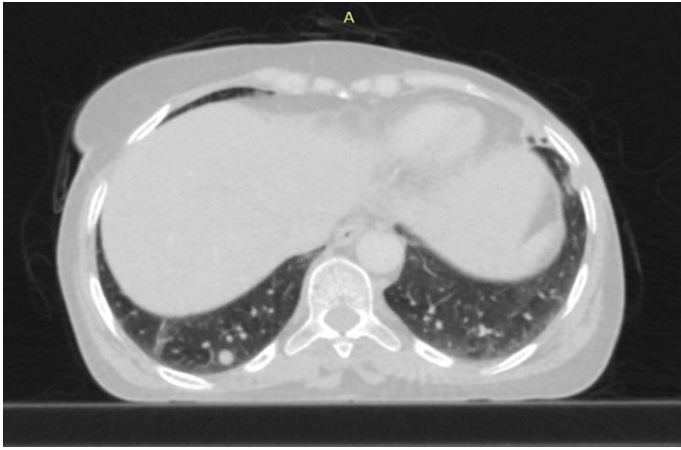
HRCT Thorax (CORADS-2): A small soft tissue lung nodule (Metastatic lesion), of size 8 x 6mm noted in posterior basal segment of right lung lower lobe
